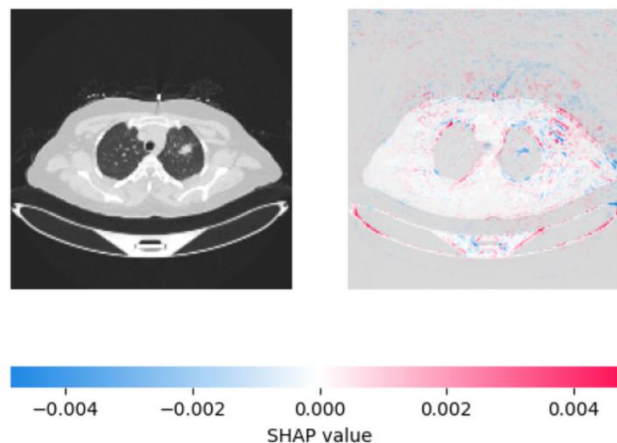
Based on the high SHAP value displayed in explanation image (second image), we can say the CT image is diagnosed as non-cancerous.
